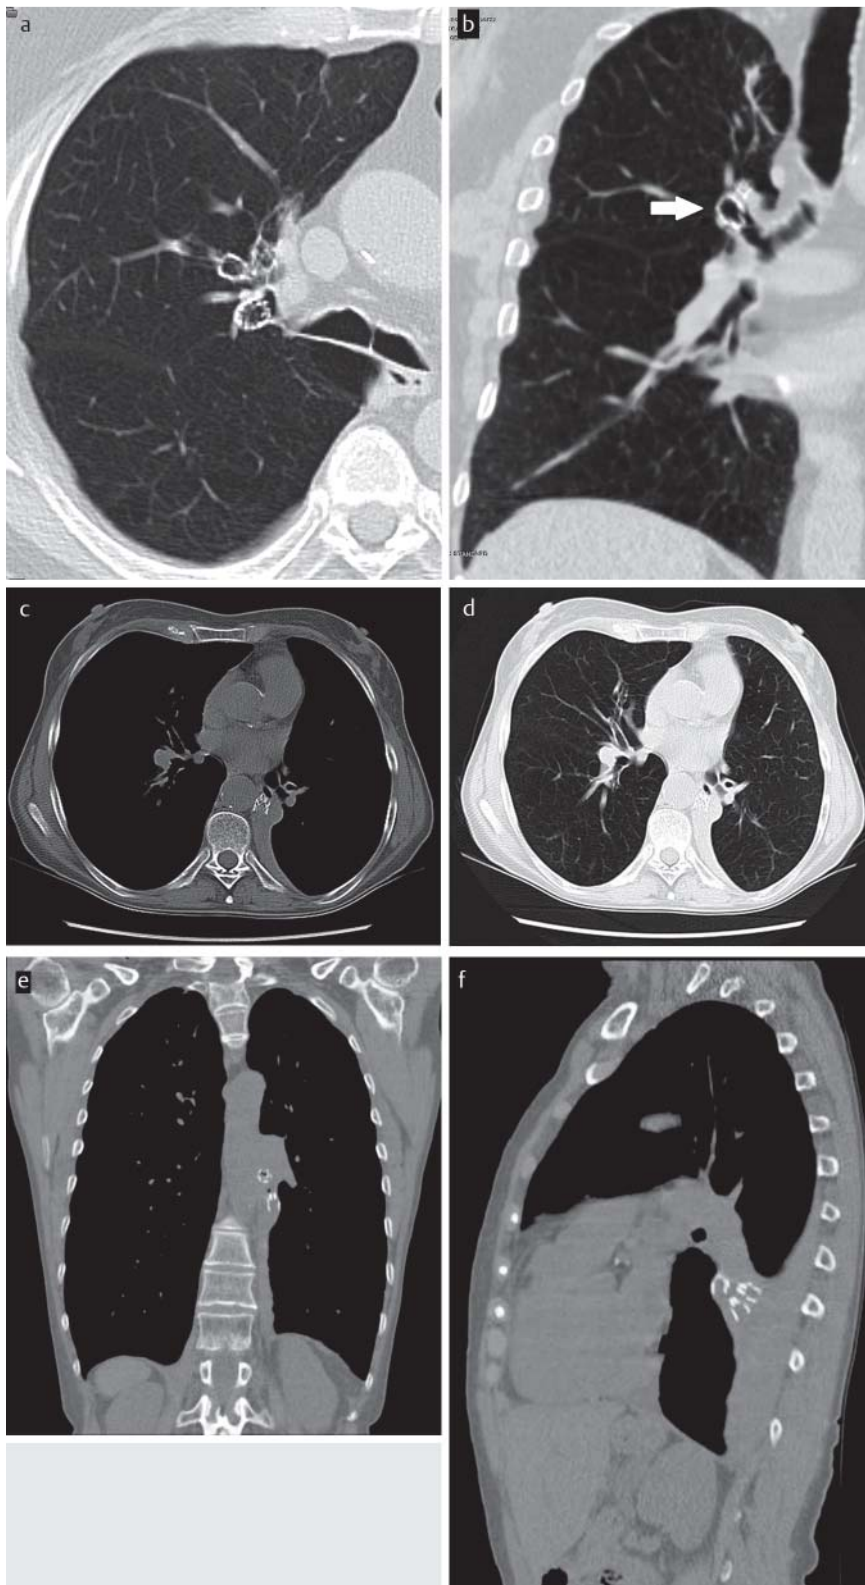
shows CT images of endobronchial valves. a, b are axial a and coronal b images showing valves lying in the right superior lobe of a 63-year old patient 14 days following implantation. The arrow in b points to the valves. The images in 2a-c and 7a were taken from the same patient. c-f show valves in place with complete atelectasis of the left superior lobe 96 days following implantation in axial (a soft tissue window, b window), as well as in coronal c and sagittal d multi-planar reformatting.
